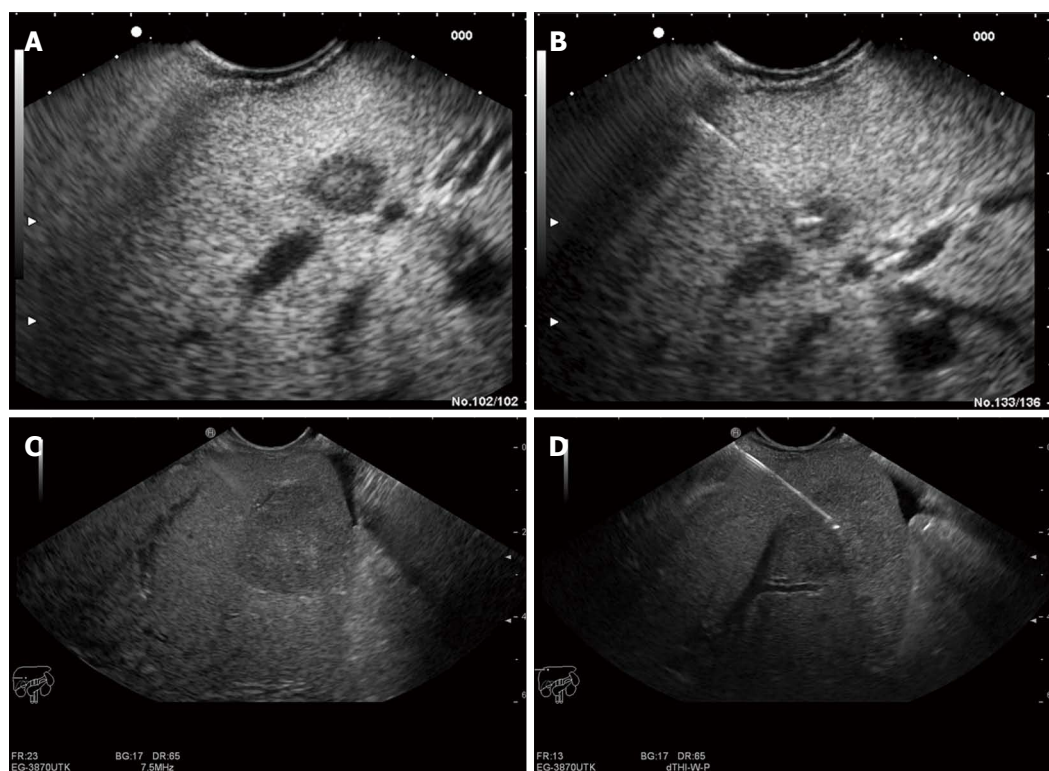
Endoscopic ultrasound image of lesion in the liver. A: Endoscopic ultrasound (EUS) image of an 8 mm metastatic lesion in the liver; B: Endoscopic ultrasound (guided biopsy from the same lesion; C: EUS image of a 25 mm lesion in the liver; D: EUS guided aspiration biopsy from the same lesion.
